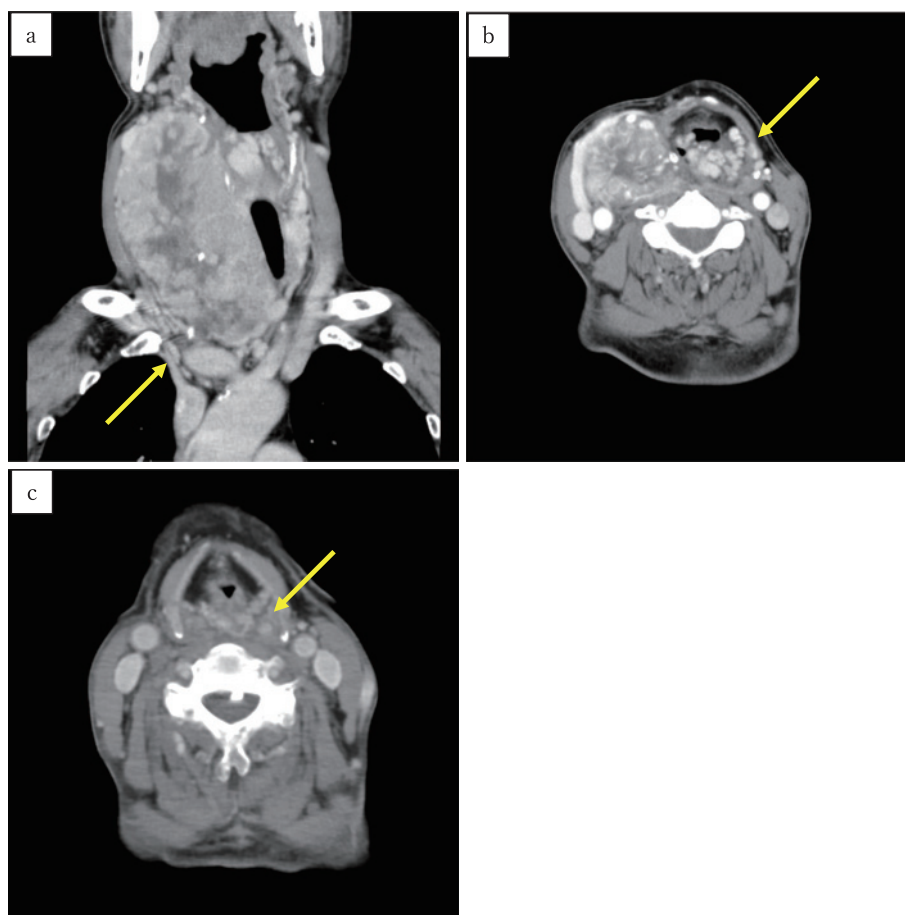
Contrast-enhanced computed tomography scans of the neck
